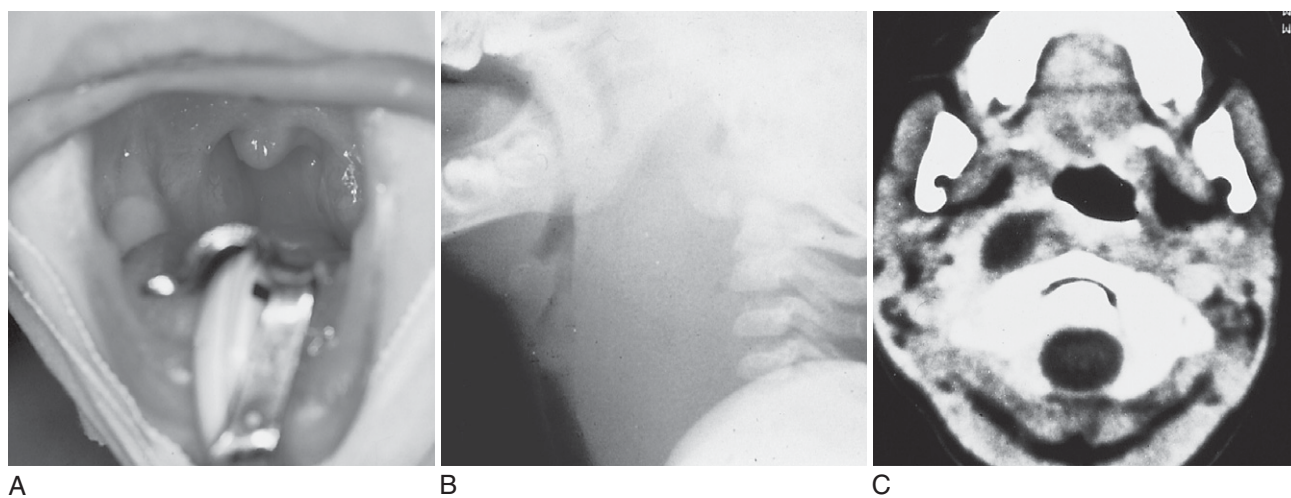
Retropharyngeal abscess. A, Intense erythema and swelling of the posterior pharyngeal wall. B, Lateral neck film showing prominent prevertebral soft tissue swelling that displaces the trachea forward. C, Computed tomography scan with contrast revealing a thick-walled abscess cavity in the retropharyngeal space. (From Zitelli B, Davis H, eds: The Atlas of Pediatric Physical Diagnosis, 4th ed. Philadelphia: Elsevier, 2002.)
